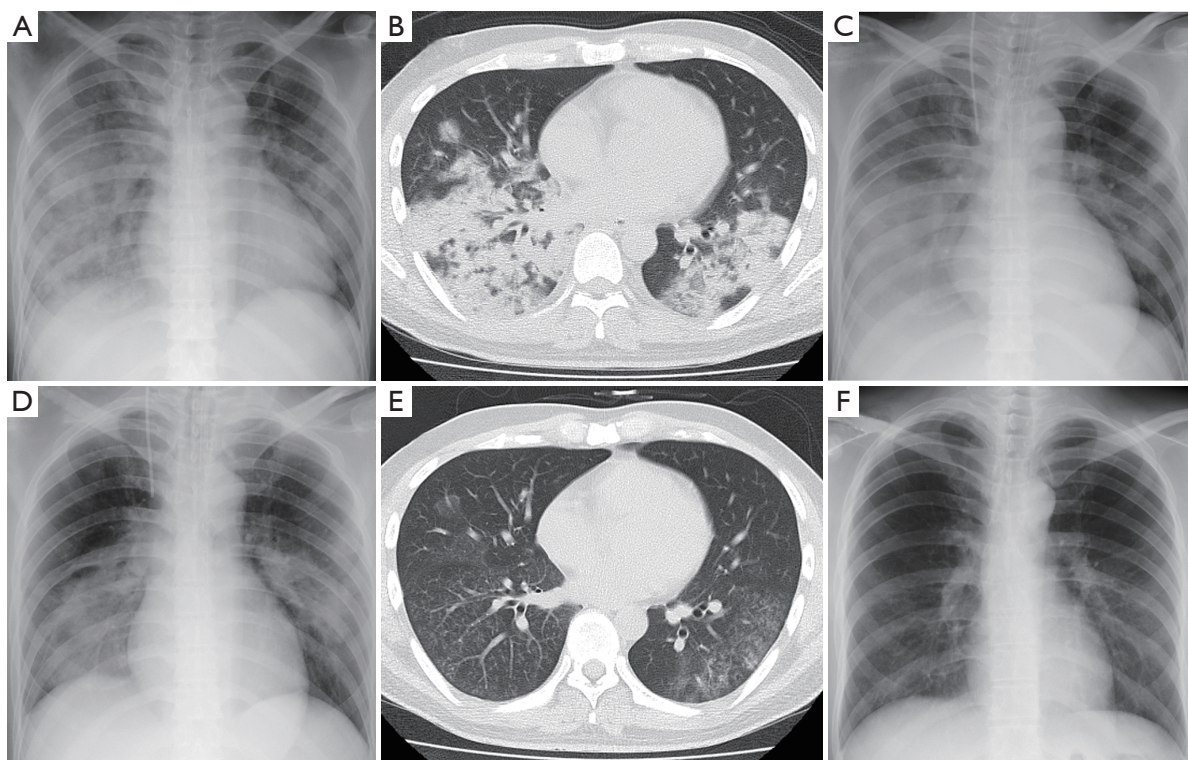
Chest X-ray (A, C and D: antero-posterior; F: postero-anterior) and computed tomography (CT) (B and E) findings. (A) and (B): Diffuse air-space consolidation predominantly in the right lung on admission to our hospital (day 1); (C) Worsening of pre-existing lung infiltration one day after initiation of the treatment using levofloxacin (LVFX) (750 mg/day) with meropenem (3 g/day) (day 2); (D) Marked improvement during corticosteroid treatment (day 5). (E) and (F): Further improvements after administration of LVFX in a total period of two weeks (day 22). CT (E), but not X-ray (F), detected only indistinct micronodular infiltration.
